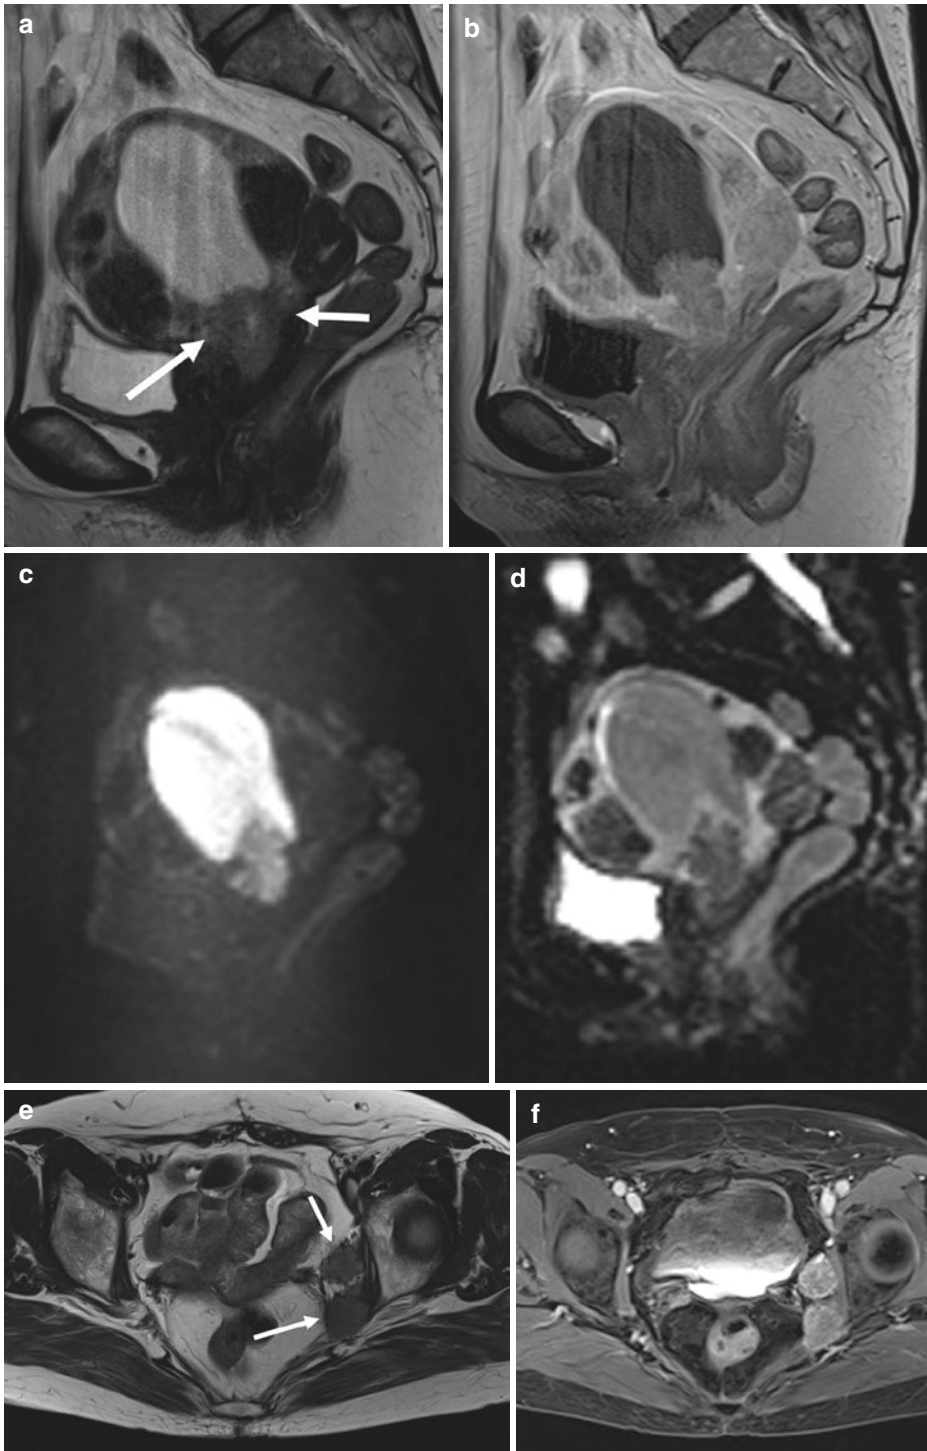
63-year-old woman with hematometra. Sagittal (a) T2WI, (b) gadolinium-enhanced T1WI, (c) DWI, (d) ADC map. Tumor was located at the cervical OS and invaded to myometrium and cervical stroma (arrows). The tumor was diagnosed as endometrioid adenocarcinoma, Grade 2, stage IIb and treat by surgery. Mean ADC values
